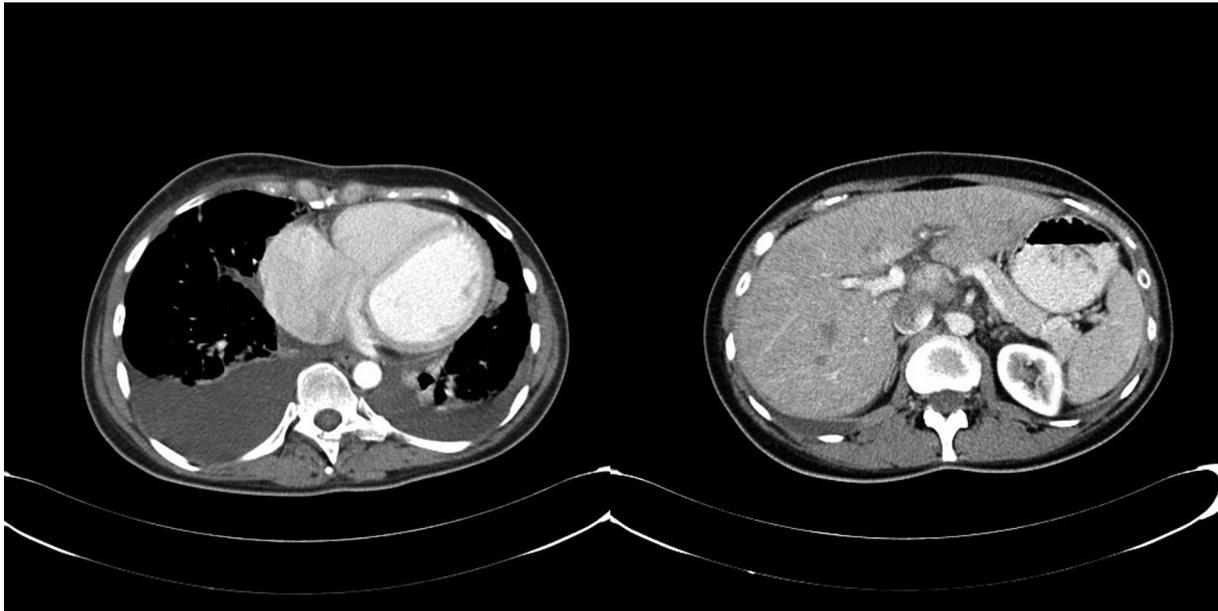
Enlarged heart, pleural effusions, and periportal oedema as signs of heart failure on CT of thorax and abdomen.
